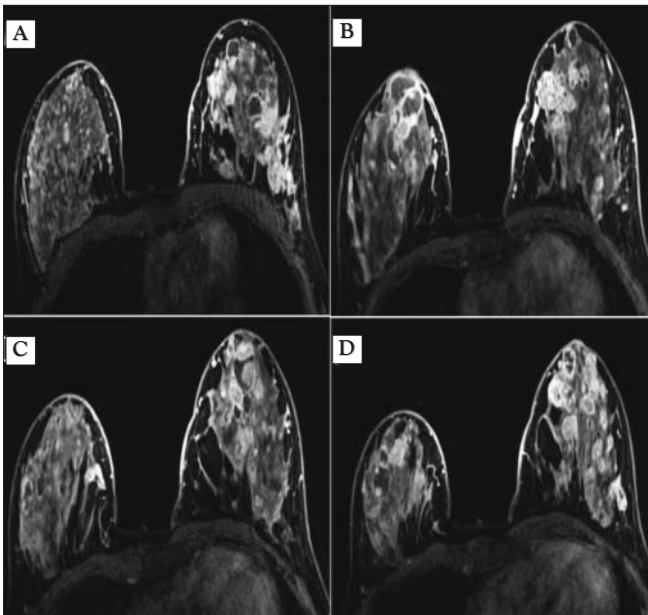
In post-contrast T1-weighted images, complex cysts that show contrast involvement on the wall in both breasts, sometimes have a dense content and show mural component on the left breast
